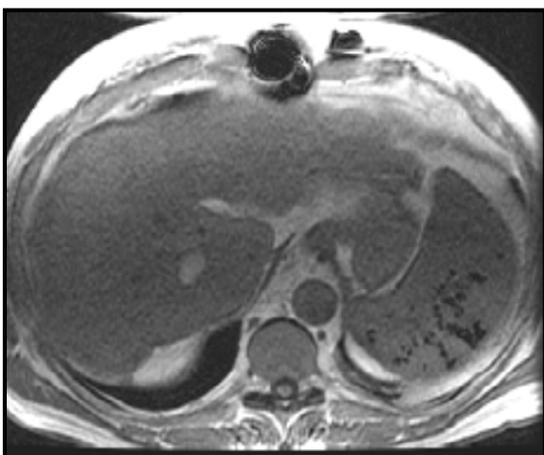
IVC encirclement by caudate lobe hypertrophy, depicted on a T1-weighted axial image obtained during routine preoperative MRI of the abdomen.
